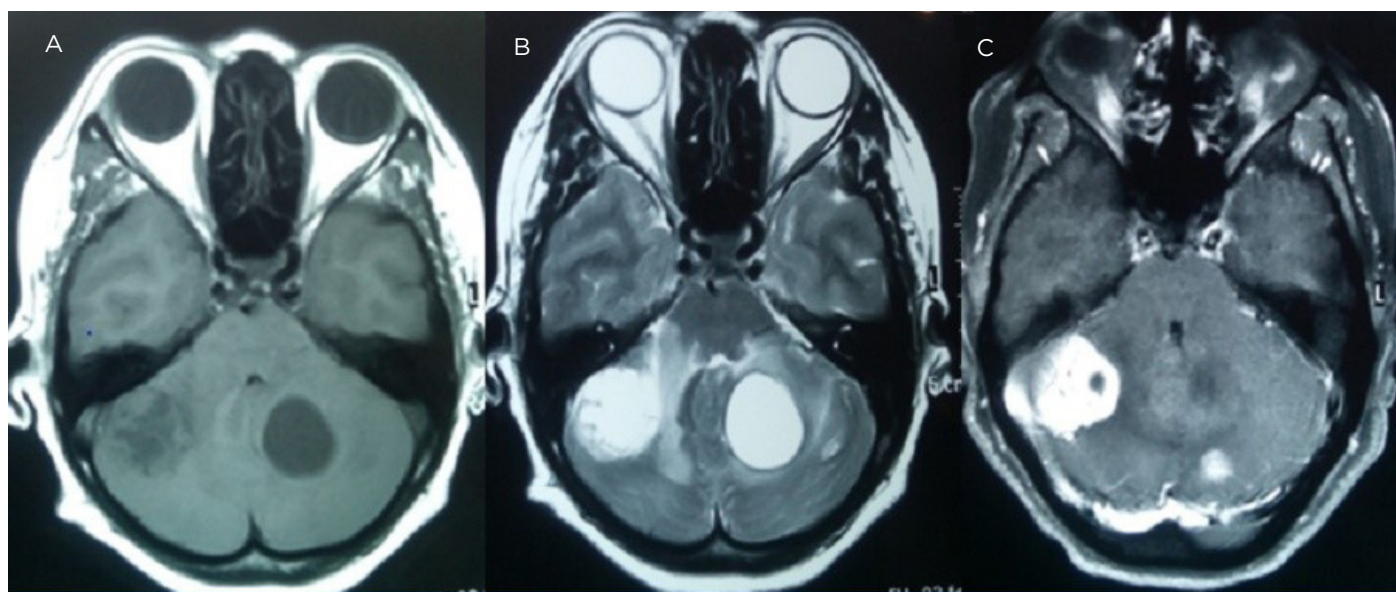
Characteristic magnetic resonance imaging findings of the lesions with enhancement.
